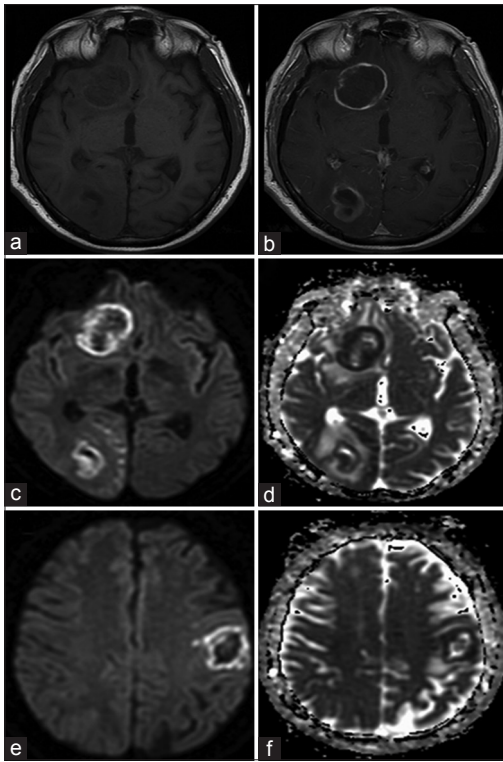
Initial magnetic resonance image of the brain shows T1 without contrast, (a) T1 with contrast, (b) diffusion-weighted imaging sequence, (c) apparent diffusion coefficient sequence, (d) diffusion-weighted imaging sequence, (e) apparent diffusion coefficient sequence, and (f) magnetic resonance image reveals ring enhancement lesions with bright diffusion-weighted imaging and dark apparent diffusion coefficient signals, suggesting intraparenchymal abscesses
